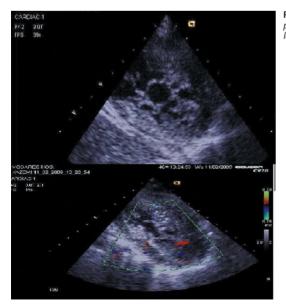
Echocardiogram shows classic appearance of isolated noncompaction of the left ventricle
